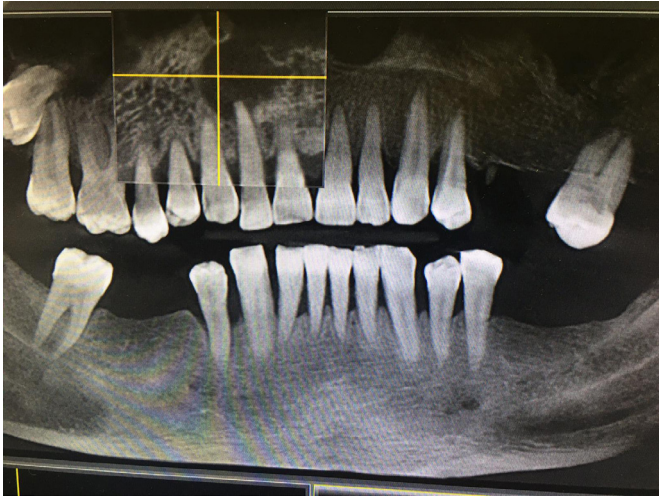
CT showing the periapical lesion at the root of the upper right lateral incisor
